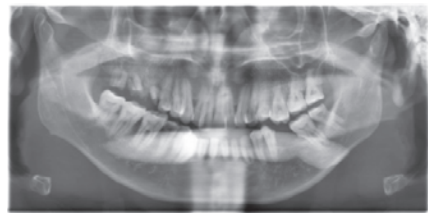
Panoramic radiograph showing a fusiform radiopaque image of 132.0mm×17.2mm size overlapping mandible extending to second molar region bilaterally.
